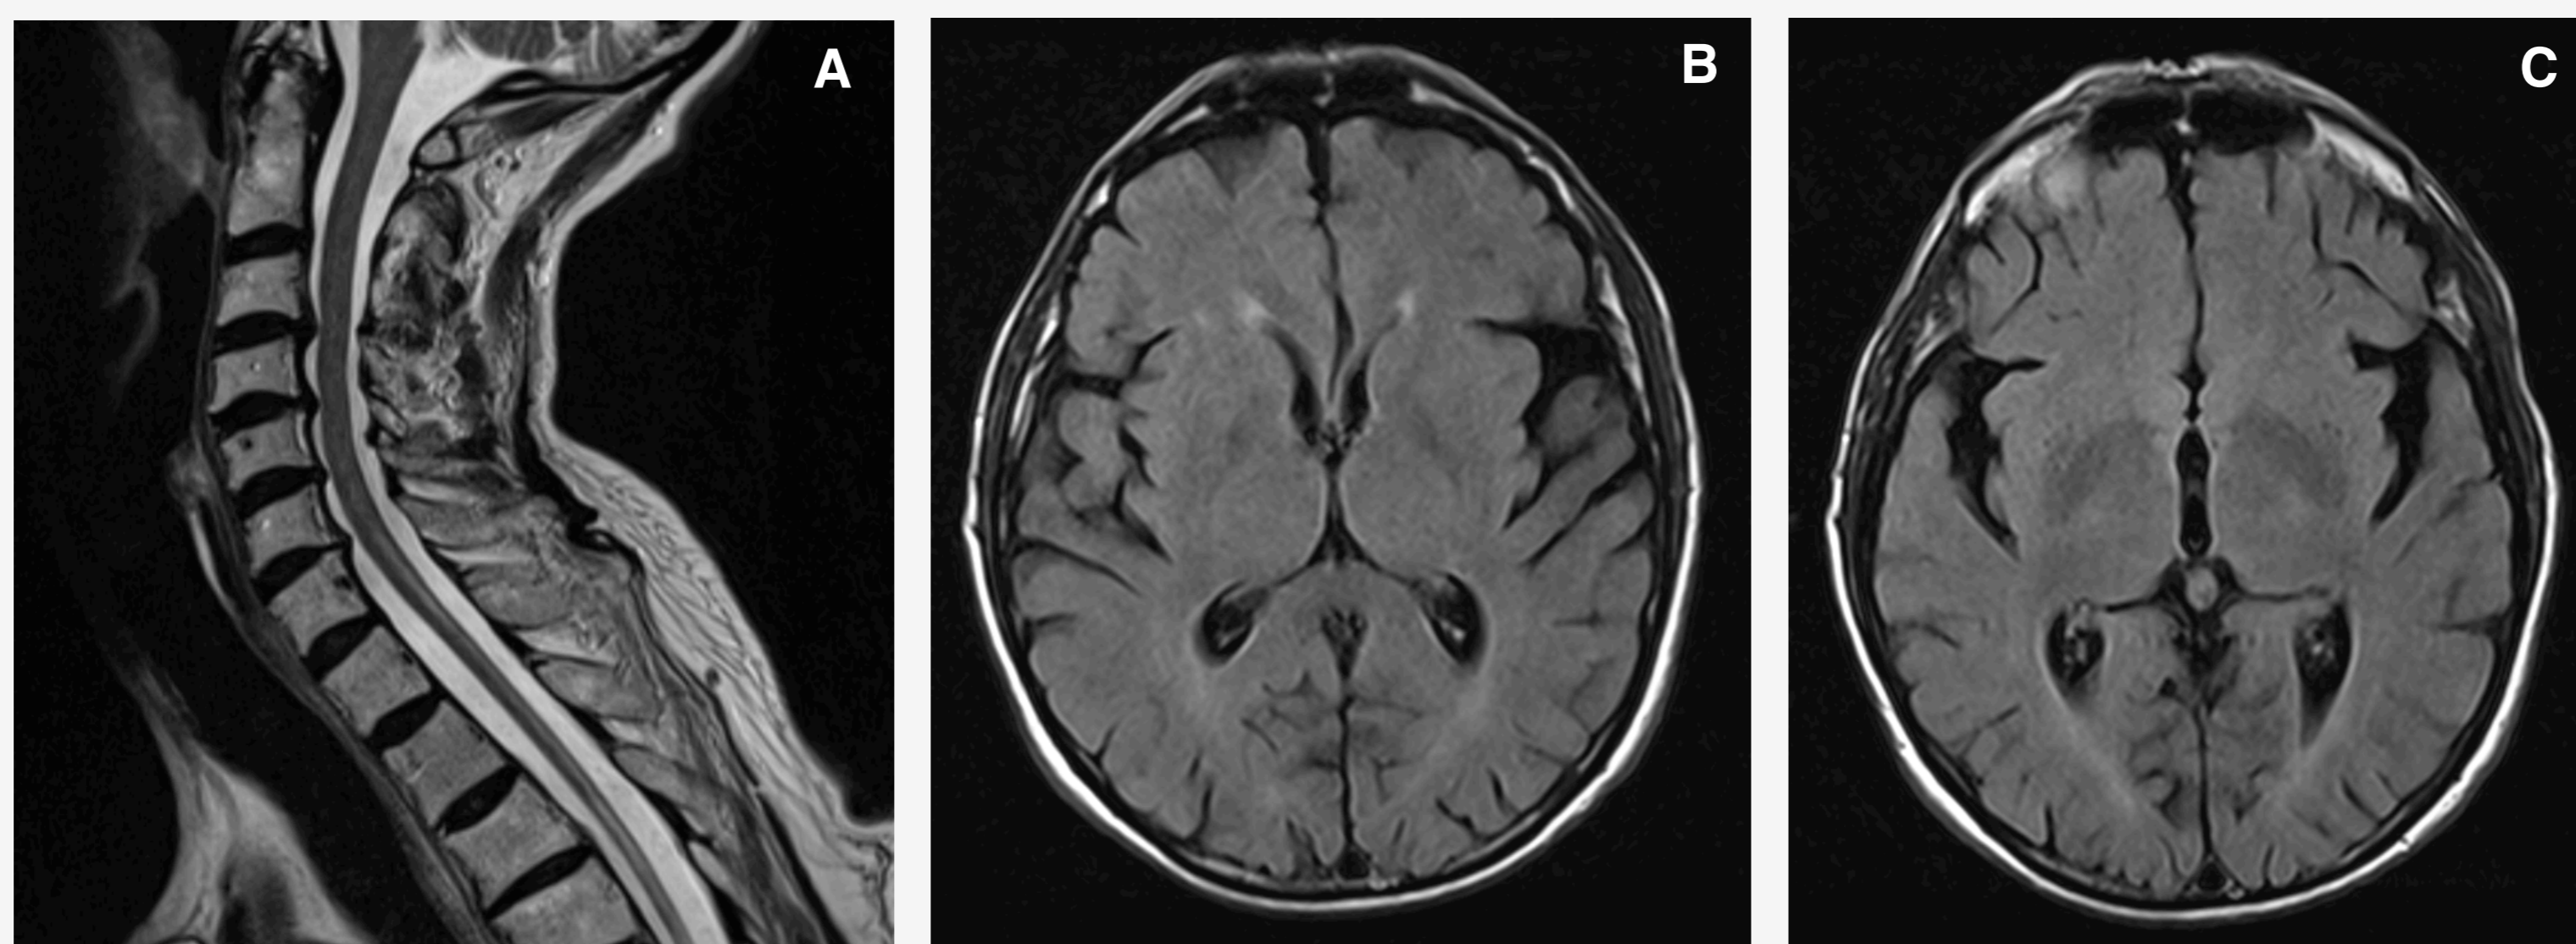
Cervico-dorsal (A) and brain MRI (B,C)
